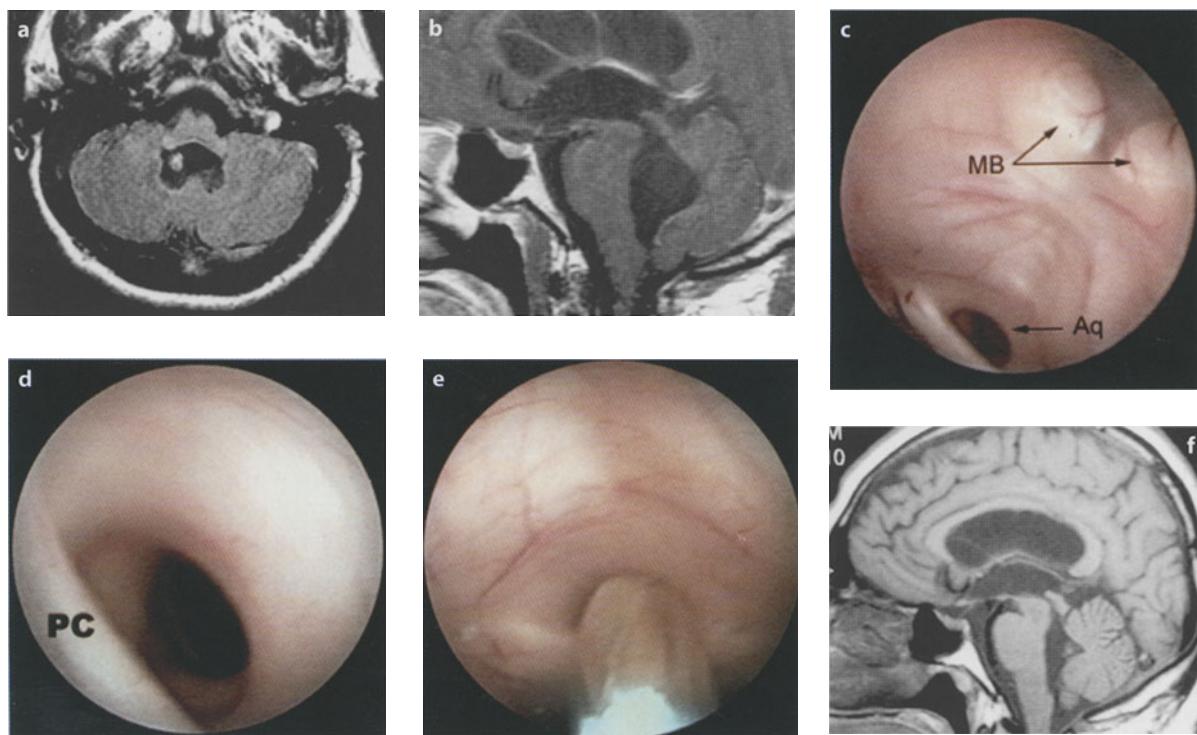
a, b Axial and sagittal T1-weighted MRI. Fourth ventricular cysticercus and scolex. c, d Endoscopic views of the floor of the third ventricle. MB, mammillary bodies; Aq, cerebral aqueduct; PC, posterior commissure. Note the cyst appearing inside the fourth ventricle. e Endoscopic view of the cysticercus being extracted. f Sagittal T1-weighted MRI, 3-month follow-up
